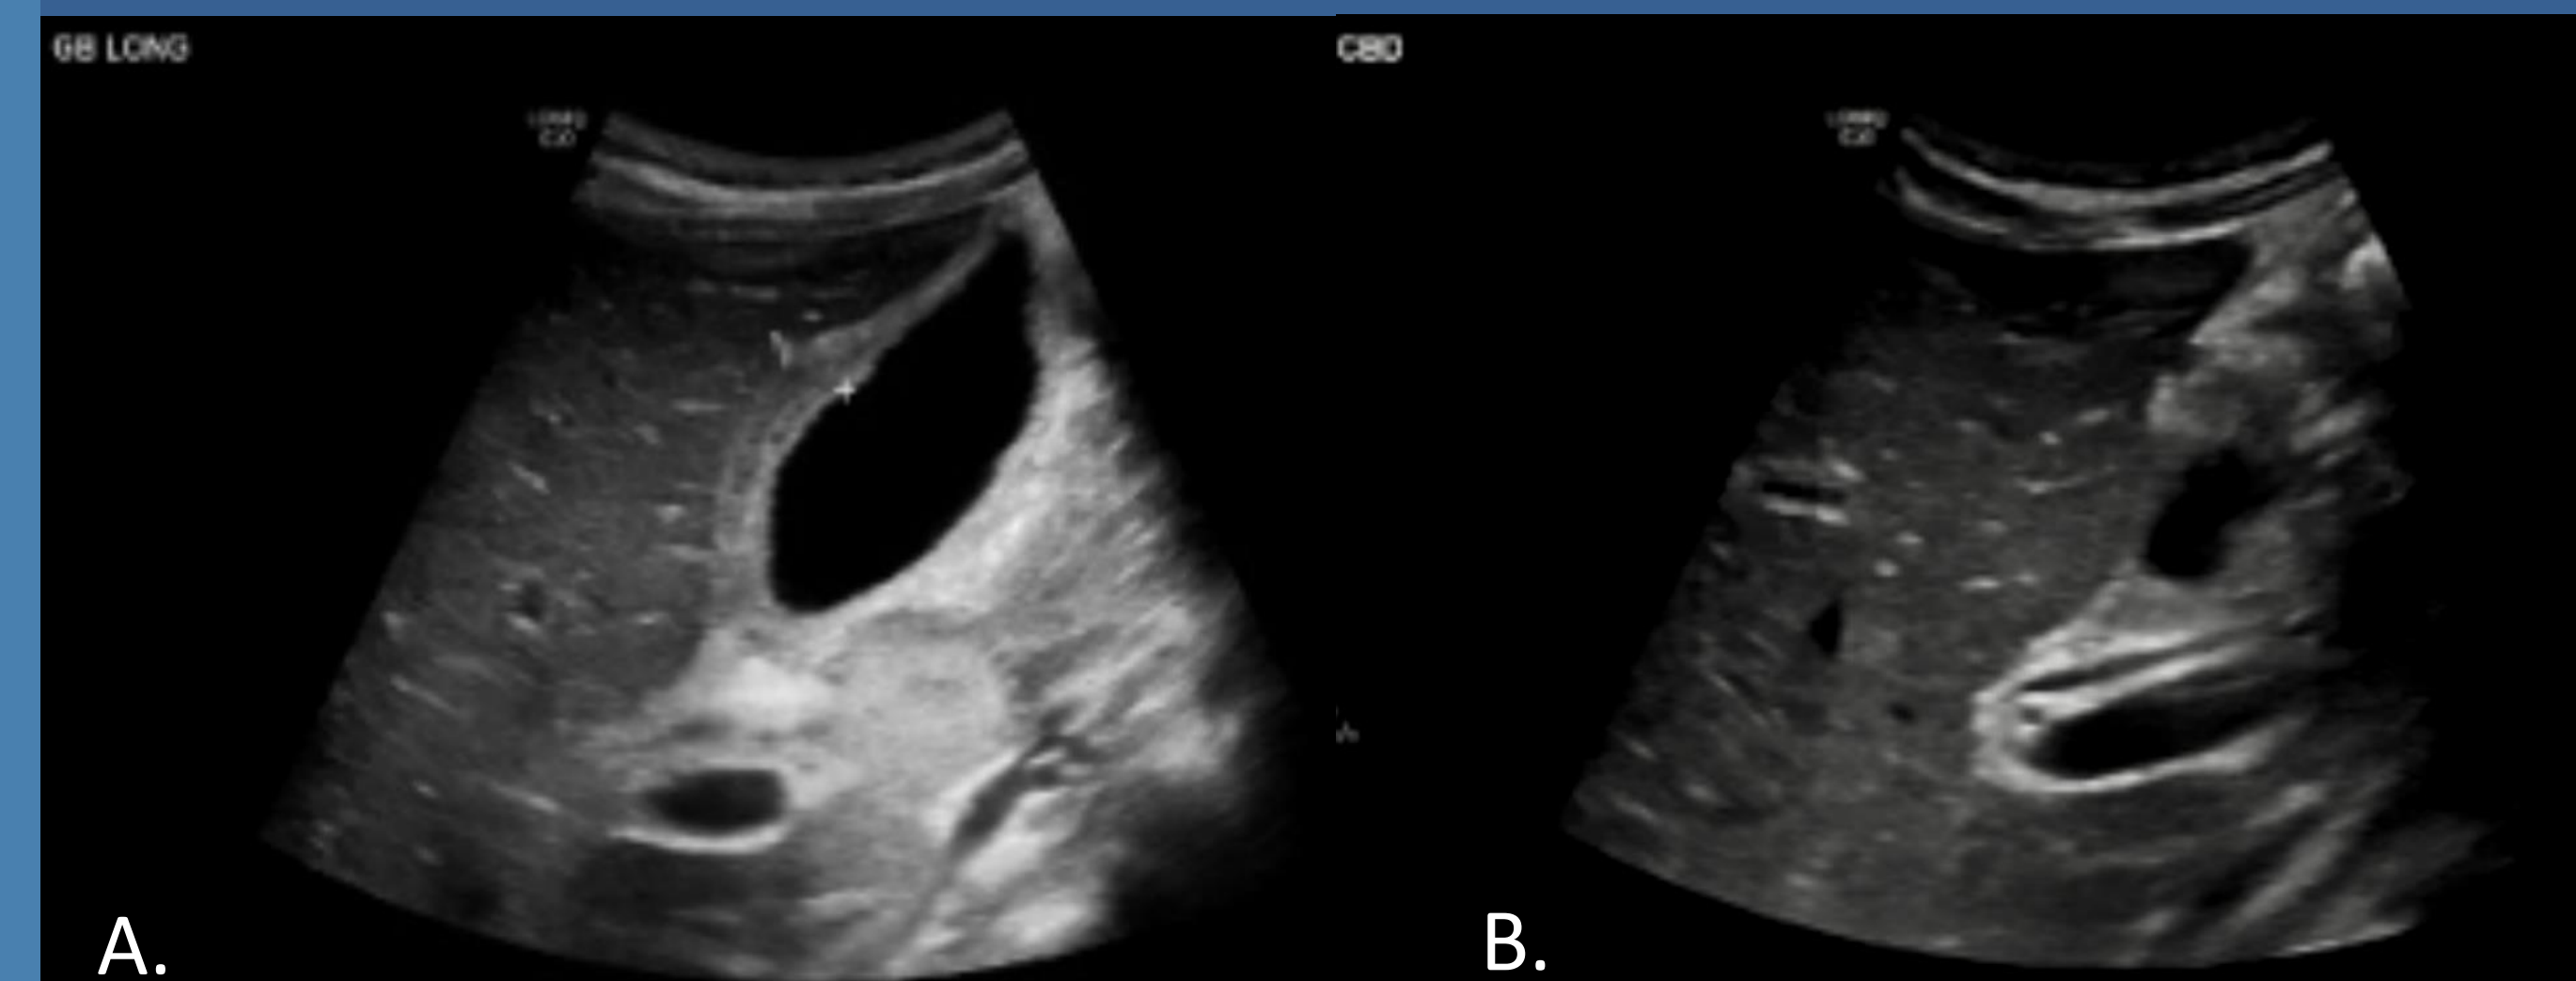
Abdominal ultrasonography taken on admission. (A) showing gallbladder thickening of 6.9 mm without any definite echogenic stone and pericholecystic fluid, (B) showing common bile duct measures 2.3 mm in porta hepatis.
